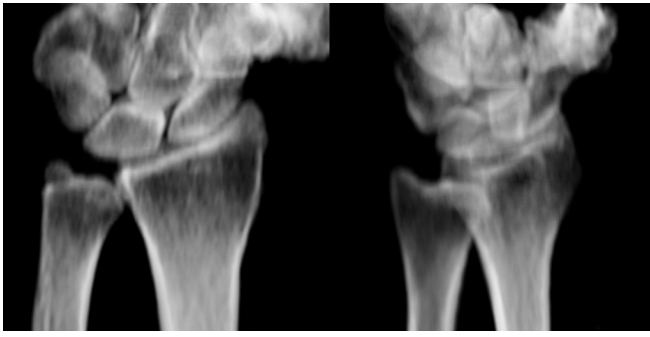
X-ray images of the wrist. The largest bone is the radius. The two smaller bones articulating immediately above the radius are the lunate and scaphoid.
